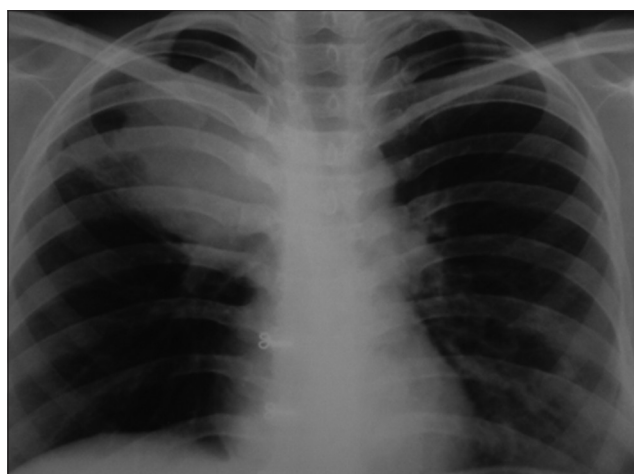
Plain X-ray chest posteroanterior view - large soft tissue opacity in right upper lobe with peripheral haziness extending to mediastinum and inferiorly to minor fissure with upward displacement of minor fissure
